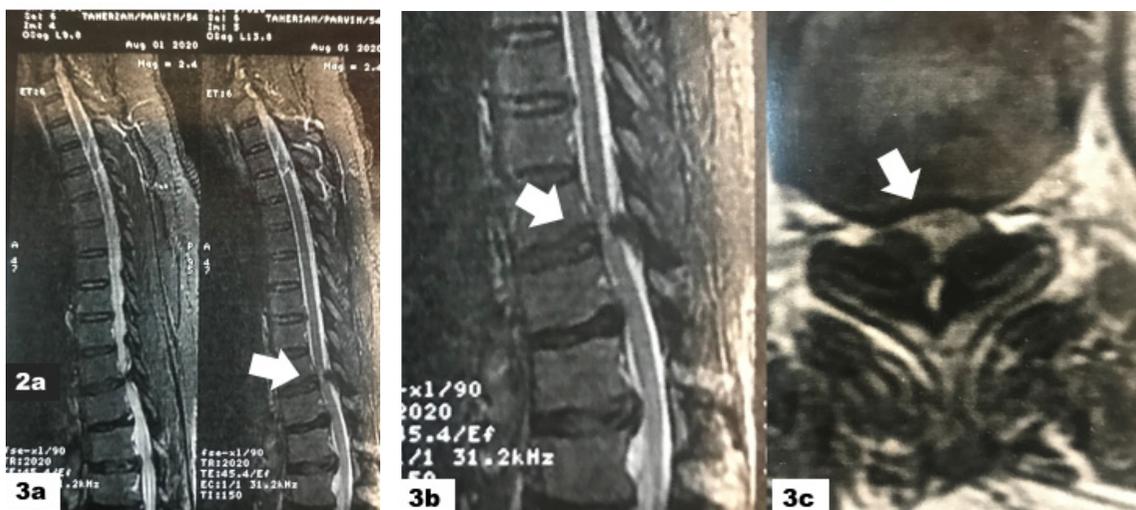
T2-weighted axial view showing bilateral OLF without myelopathy
